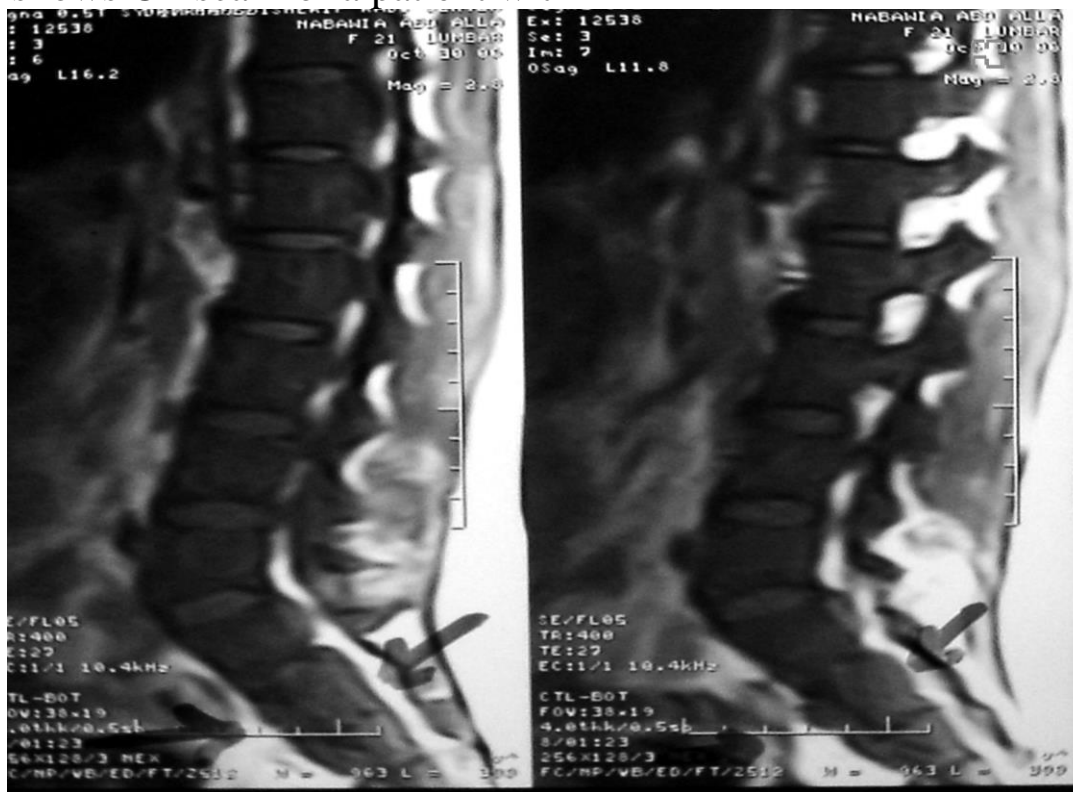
shows MRI of the same patient with EMH
